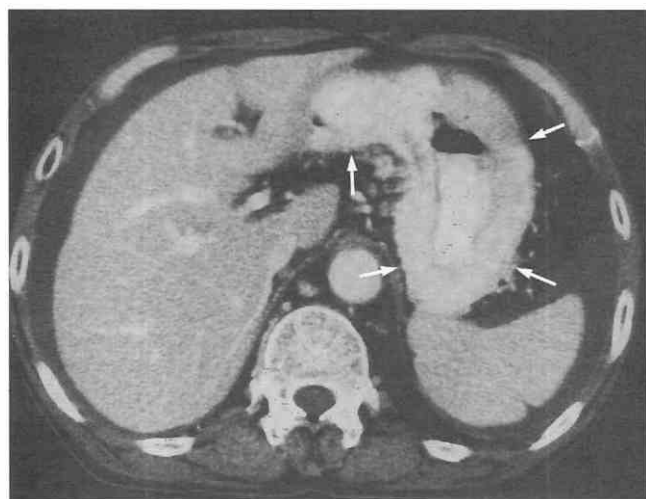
Scirrhous adenocarcinoma of the stomach. CT scan shows considerable gastric wall thickening (arrows) with a markedly enhanced submucosal layer and a poorly enhanced thin rim of mucosal layer. Ascites is also seen.
